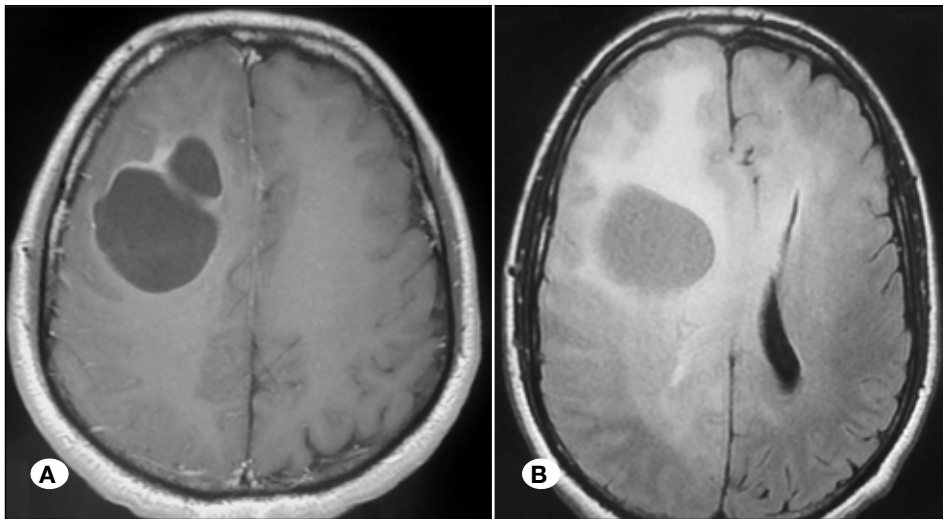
Axial T1-weighted brain MRI with gadolinium demonstrating transient enhancing binocular cyst in the right frontal lobe (A). FLAIR sequence showing edema surrounding the lesion and midline structures shifted to the left side (B).
